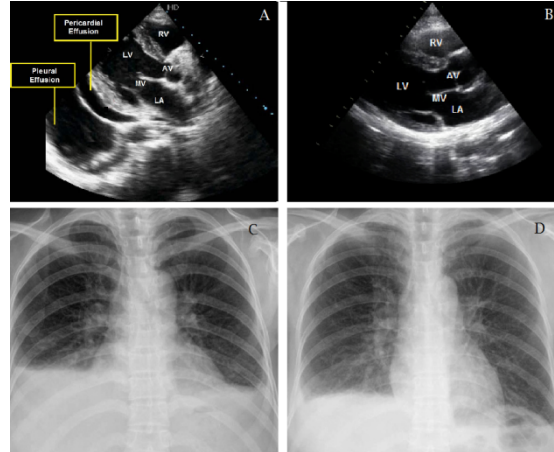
(A) before treatment- 2D Echo PLAX view showed pericardial and pleural effusion. (B) after treatment-2D Echo PLAX view showed clear. In figure-3 (C) before treatment- X-Ray chest PA view showed pericardial and pleural effusion. (D) after treatment- X-Ray chest PA view showed clear.
